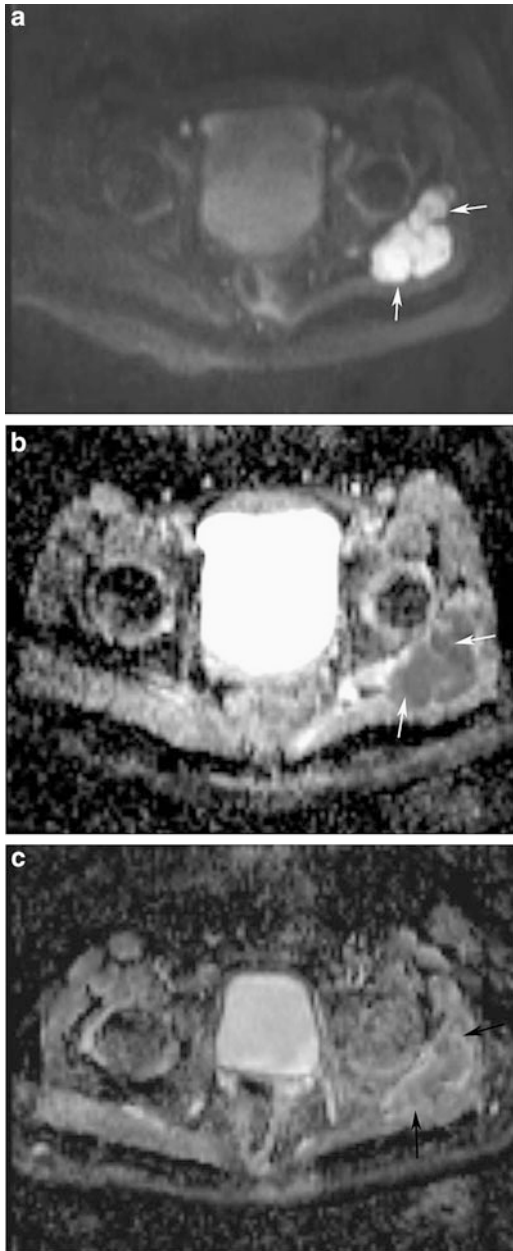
Axial DWI (a) and corresponding ADC map (b) in a 9-year-old boy with confirmed synovial sarcoma of the gluteal muscles (same patient as in Fig. 10.10) revealed restricted diffusion in the lesion as evidenced by bright signal on the DWI images and corresponding low ADC values (white arrows). ADC map after three rounds of chemotherapy (c) demonstrates decreased size of the lesion (arrows) and slight increase in the ADC values
